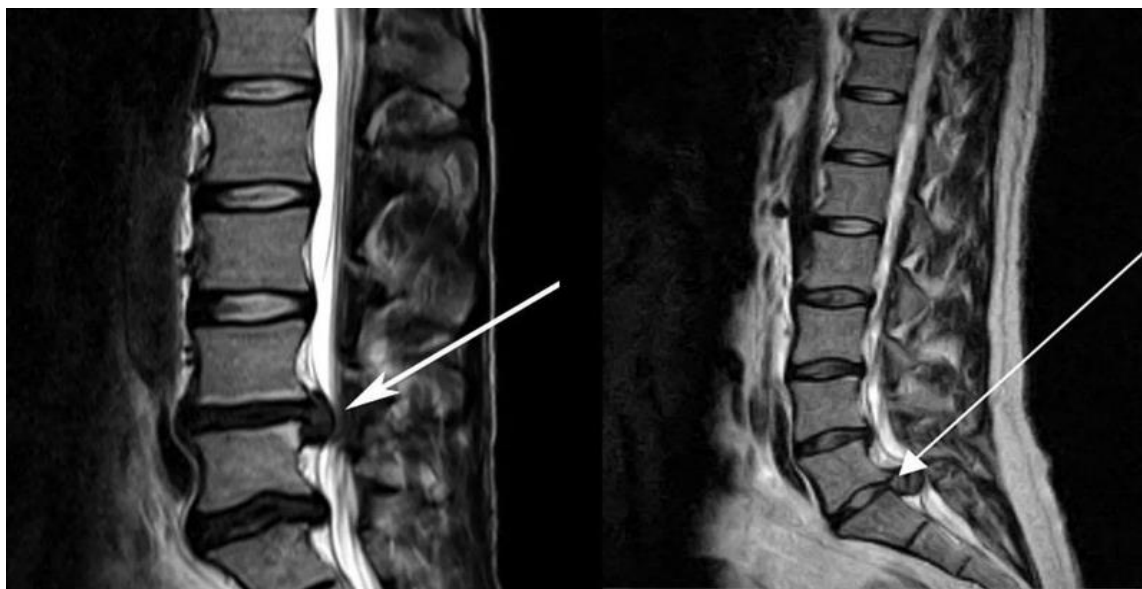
MRI signs of a hernia of the lumbar spine.
